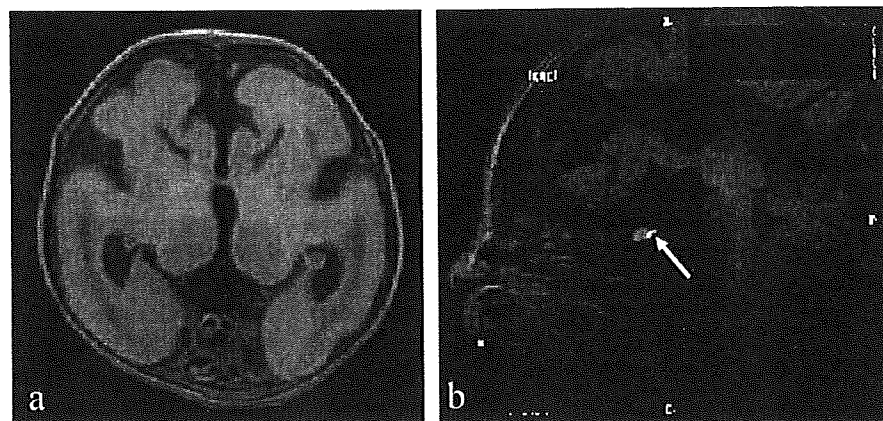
Brain MRI findings at the age of 1 day. Axial view of T1-weighted image demonstrated total absence of the corpus callosum and lissencephaly, consisting of frontal pachygyria and posterior agyria (a). Sagittal view of T1-weighted image demonstrated normal high signal in the posterior lobe of the pituitary gland (arrow) (b).
